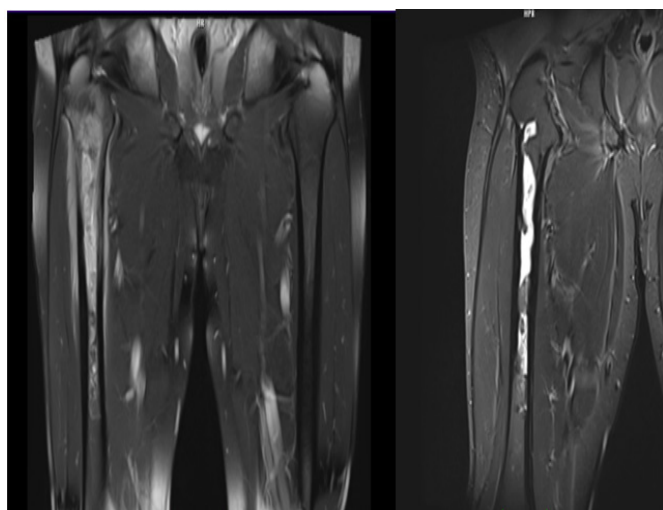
Femur MRI images of the patient before and after treatment
